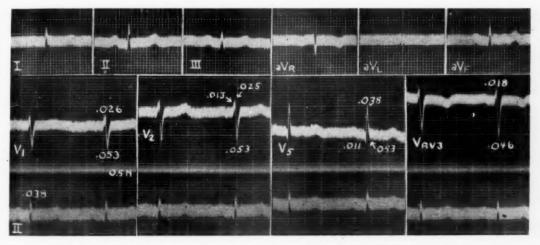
Patient with normal heart whose x-ray film is shown in Fig. 7. Leads I, II, III, aV_R, aV_L, and aV_F were recorded at normal sensitivity. Leads V₁, V₂, V₅, and V_{RV3} (right ventricular cavity with electrode at Point 3, Fig. 7) were recorded at half-normal sensitivity simultaneously with standard Lead II at slightly less than normal sensitivity of the string. The figures on the curves represent the time in seconds of the deflections over which they are written with reference to the beginning of QRS in Lead II. The time lines in the upper row occur every 0.04 second; in the lower two, every 0.2 second. To be noted are the similarity of Leads V₁, V₂, and V_{RV3} except for the direction of the T wave.
